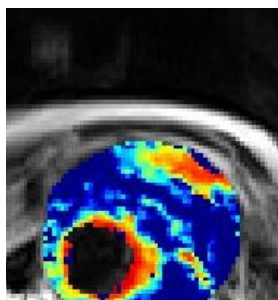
Colour map of magnetic resonance imaging of an abdominal aortic aneurysm. Red and yellow pixels indicate areas of increase T2* value, indicative of USPIO uptake.
